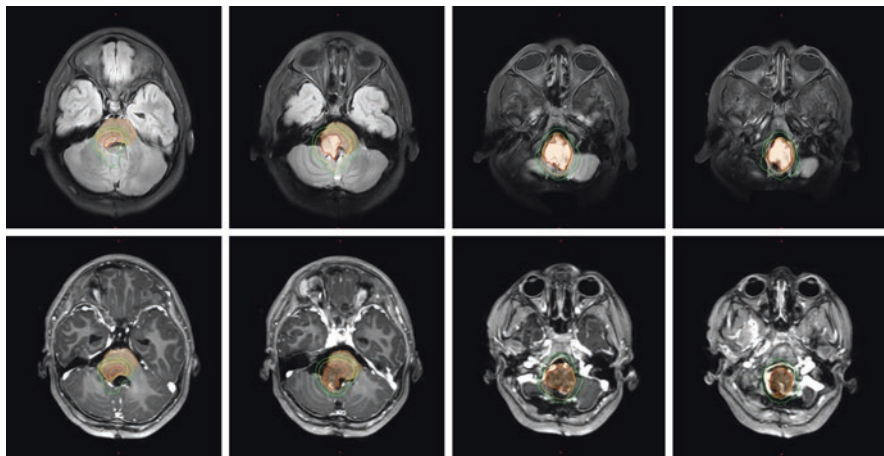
Contours for a patient with low-grade intrinsic ganglioglioma involving the brainstem, WHO grade I. GTV, red; CTV, yellow; PTV, green. Top row, T2 FLAIR axial MRI sequences; bottom row (T1 3D post-contrast axial MRI sequences)
